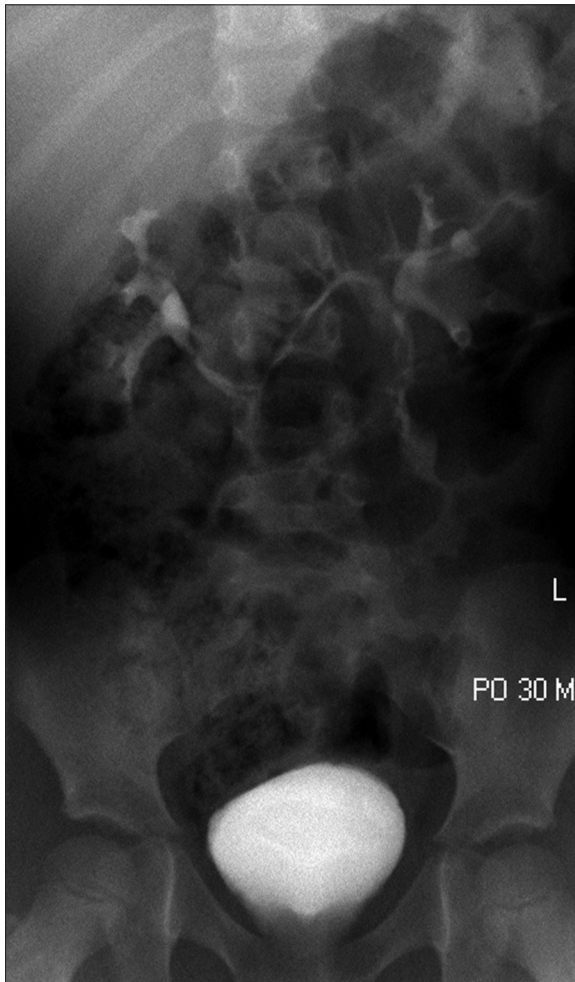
Conventional X-ray urography revealed displacement of the collecting system in the central part, without urinary flow obstruction.
